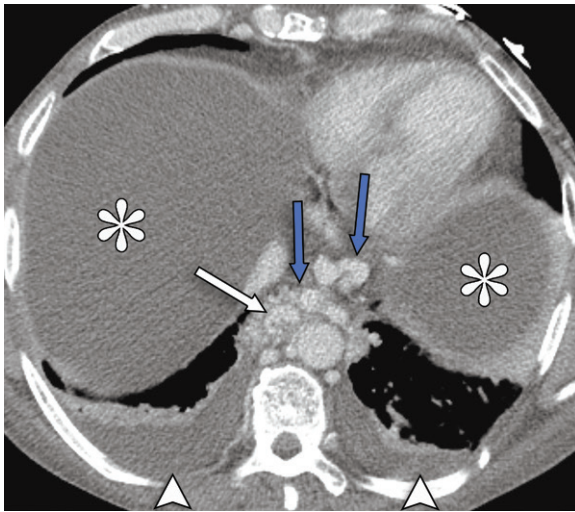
Esophageal and paraesophageal varices in a 63-year-old man with decompensated cirrhosis, portal hypertension, and anemia. Axial portal venous phase CT image shows submucosal esophageal varices (white arrow) and paraesophageal varices (blue arrows). Also noted is a large amount of ascites (*) and small bilateral pleural effusions (arrowheads).
